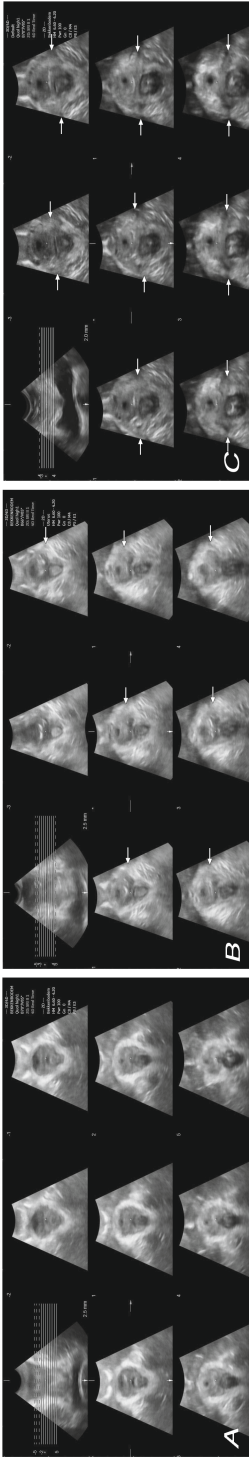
Example of a normal levator ani muscle (A), unilateral (B), and bilateral (C) avulsion of the levator during pelvic floor muscle contraction with perineal pelvic floor ultrasound. Arrow depicts site of avulsion.
